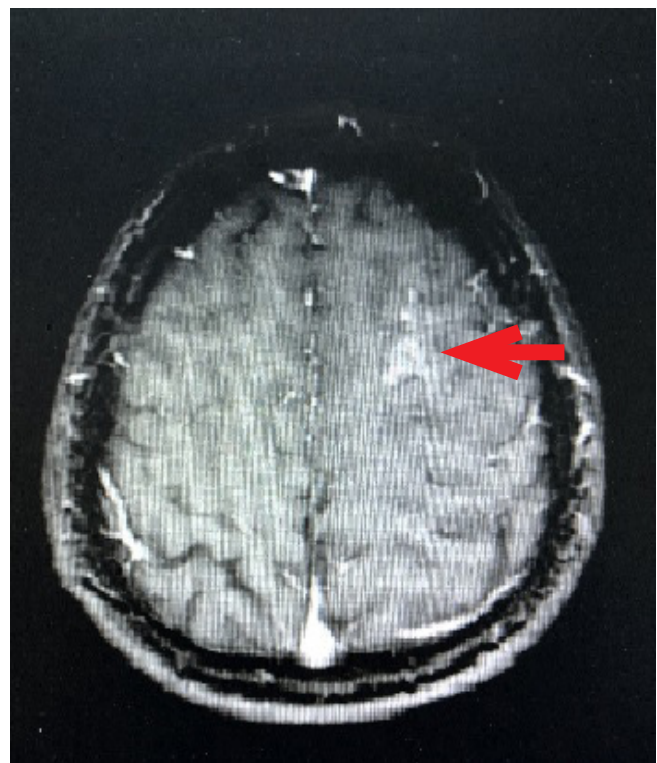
MRI scans of the brain revealing an image, which was considered primarily as hemorrhagic cavernous angioma, showed minimally heterogeneous intravenous contrast enhancement, hyperintense on T1-weighted images and heterogeneously hyperintense on T2-weighted images, and measured approximately 11 mm in size in the left posterior frontal region at high ventricular level
